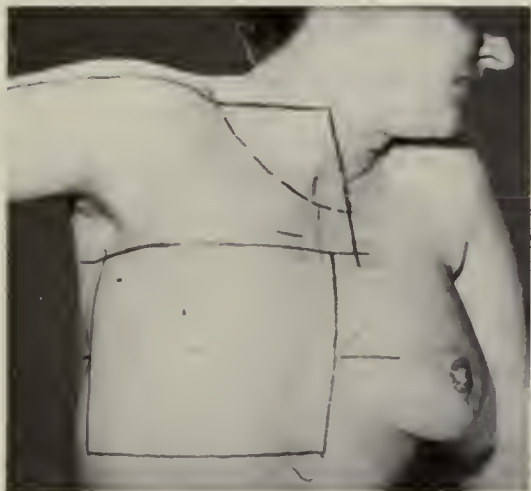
Location of fields in the McWhirter technique. (From *Am. J. Roentgenol. Radium Therapy*, 62: 339; courtesy of Dr. Robert McWhirter and Charles C Thomas, Publisher, Springfield, Ill.)
